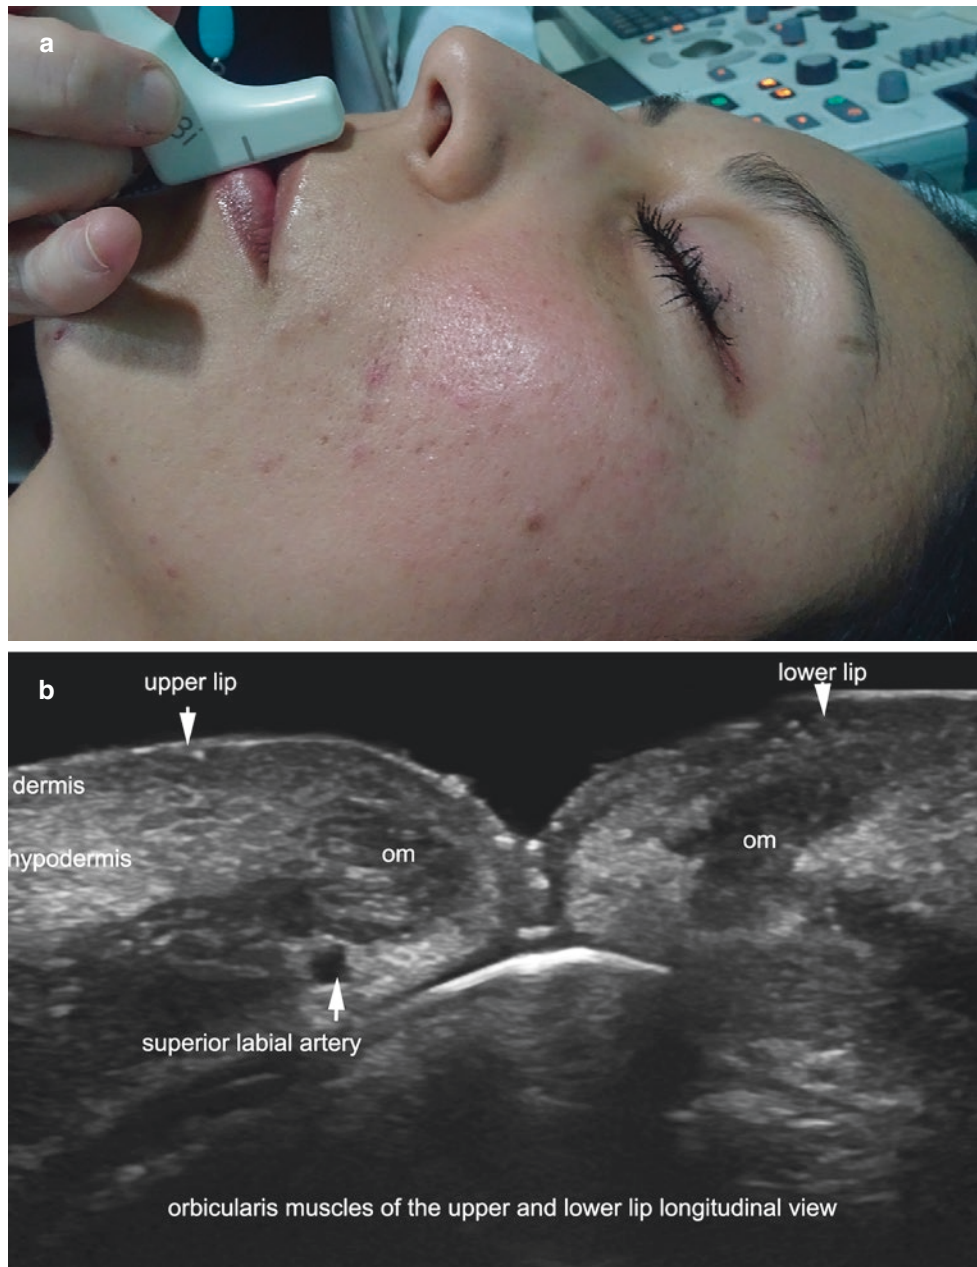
Upper and lower parts of the orbicularis oris muscle. (a) Clinical image shows the location of the probe. (b) Ultrasound (longitudinal axis) shows the hypoechoic bands of the upper and lower parts of the orbicularis muscle at the lips.
